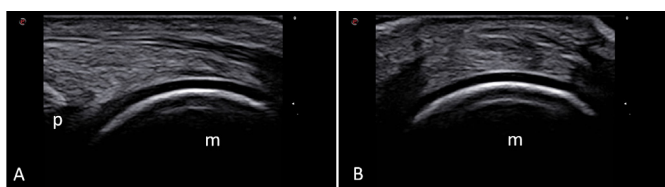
Healthy subject. Normal sonographic features of metacarpal head hyaline cartilage appearing in dorsal longitudinal (A) and transverse (B) views as a subtle anechoic layer delimited by two hyperechoic acoustic interfaces: the chondro-synovial otherwise called superficial margin which is physiologically thinner than the osteo-chondral otherwise called deep margin.
